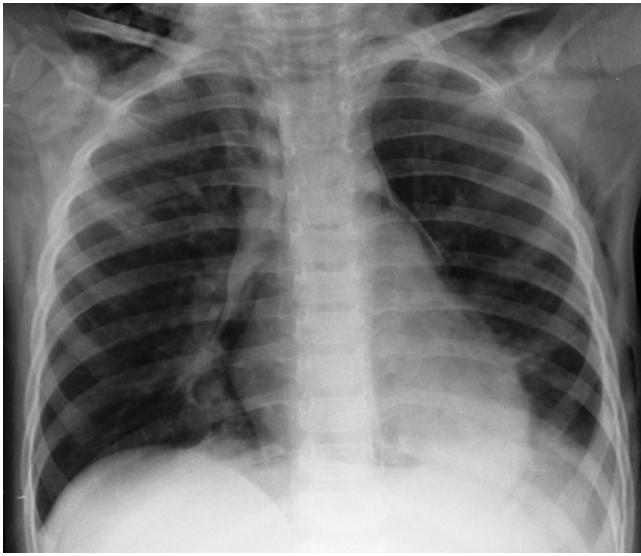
A girl aged 3 years with influenza A (H1N1) complicated by pneumonia. Chest X-ray showed pneumomediastinum, subcutaneous pneumatosis at the neck, and pneumatosis at the left thoracic wall
